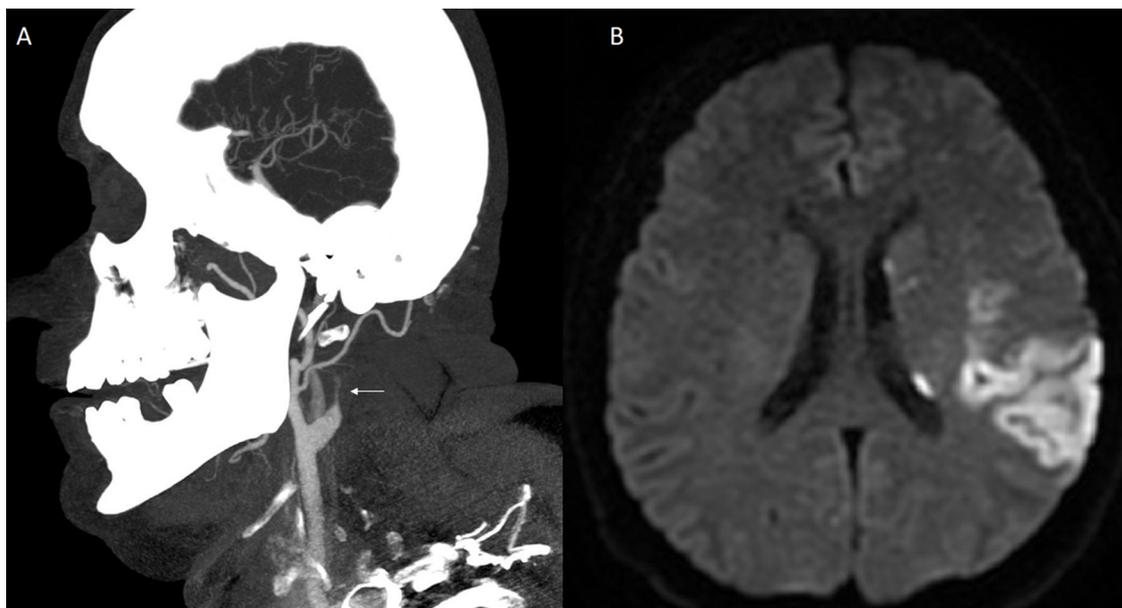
Computed tomographic angiography performed in the Emergency Department shows a progressive narrowing of the eccentric lumen of the left internal carotid artery, surrounded by a crescent-shaped mural thrombus, with complete distal obstruction. This is known as the “string sign” and suggests a dissection (arrow in 2A). Diffusion weighted imaging of the magnetic resonance imaging performed in the acute phase shows areas of restricted diffusion in the posterior territory of the left middle cerebral artery representing an acute stroke (2B).
